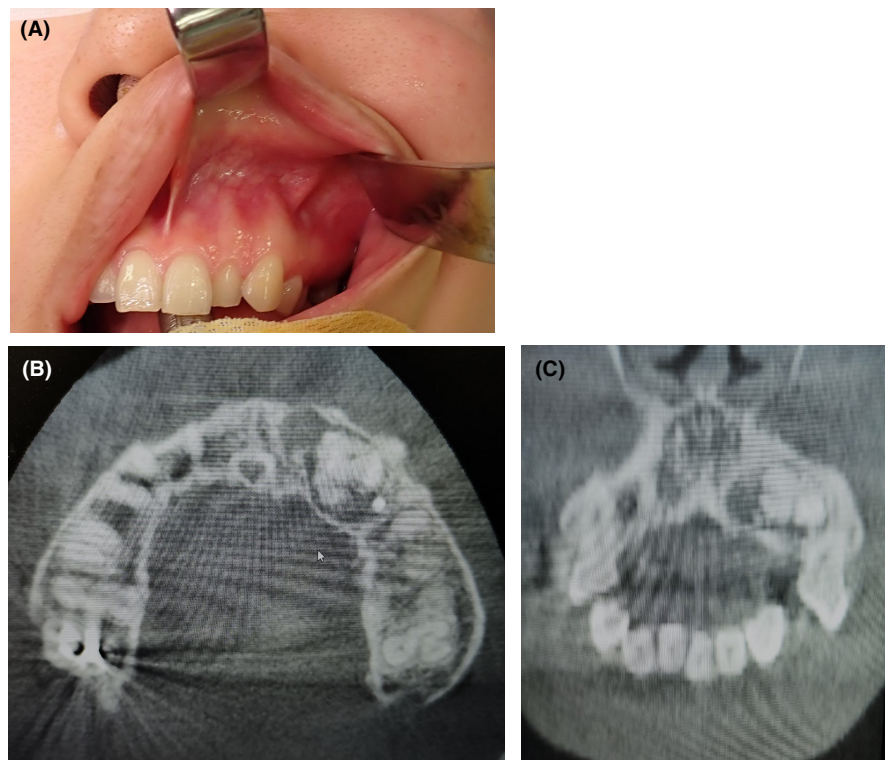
Intraoral photograph and X-ray images: (A) Intraoral photograph: A painless gingival mass in the left maxilla region. (B) Conventional CT images (horizontal plane). (C) Conventional CT images (coronal plane).
